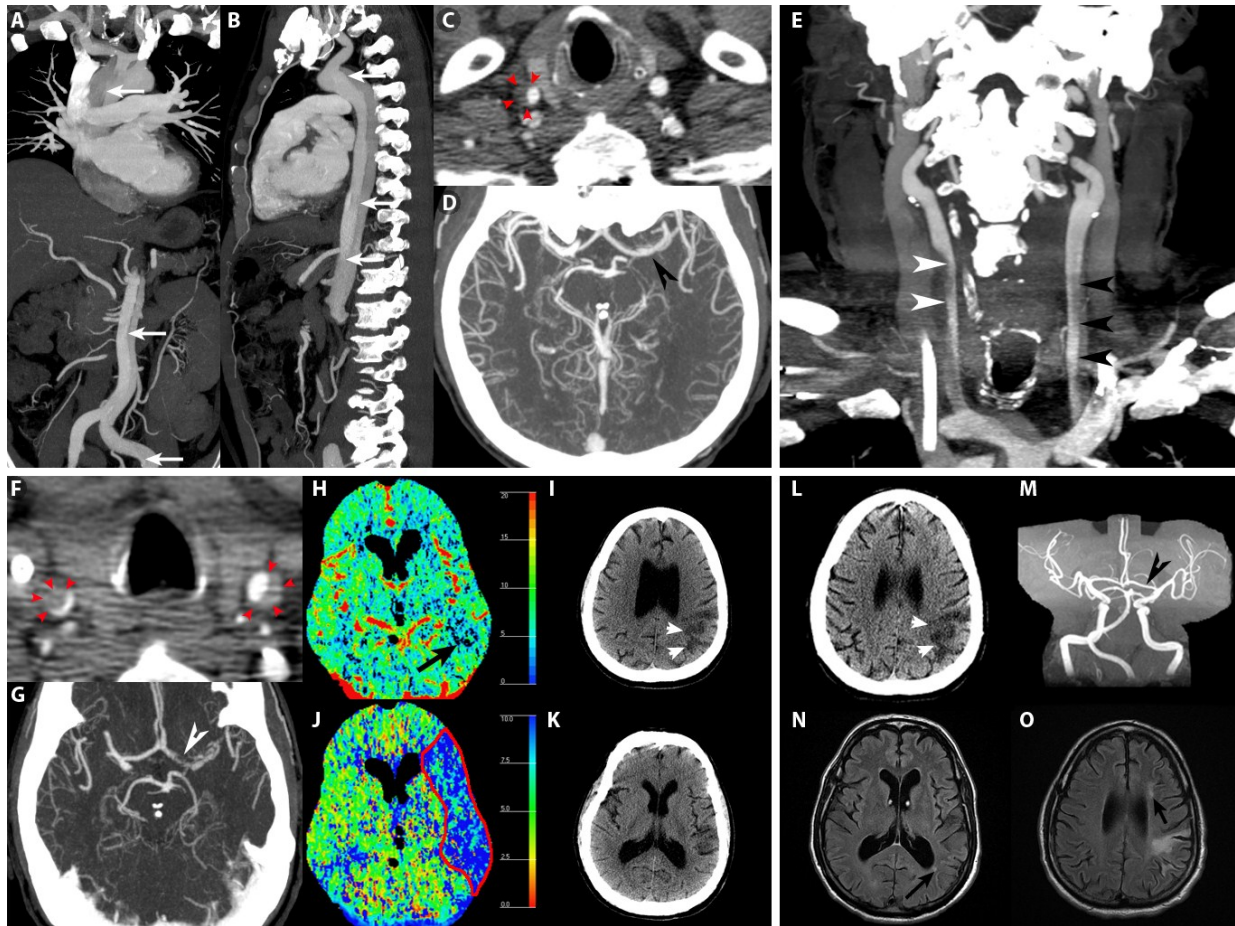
(A, B) Stanford type A aortic dissection (white arrows) on CT-angiogram. (C) Right common carotid artery (CCA) dissection with false lumen denoted by red arrowheads. (D) Patent left middle cerebral artery (MCA, arrowhead). (E) Old right (white arrowheads) and new left CCA dissection (black arrow heads) with (F) false lumen (red arrowheads) on postoperative day two. (G) Left MCA stenosis (white arrowhead). (J) Mean transit time (MTT) indicates extensive ischemia with (H) corresponding small ischemic core on the cerebral blood volume map (CBV, black arrow). (I, K) small subacute parietal infarct on postoperative day four. Four months postoperatively, CT demonstrates (L) previously noted parietal infarct and (M) MRA shows complete MCA recanalization. (N, O) MRI identifies two small new infarcts (arrows) in addition to previously visualized infarcts on CT.
